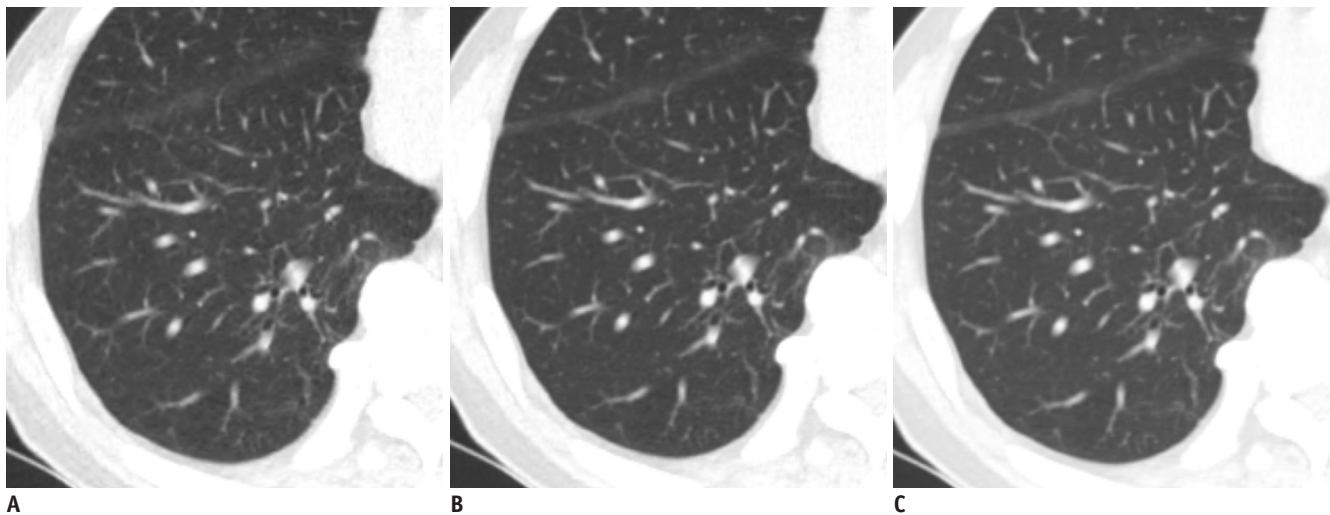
Comparison of low-dose chest CT scan in axial lung window images of lung in 73-year-old man.
